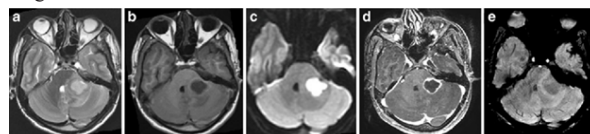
MRI Brain images
